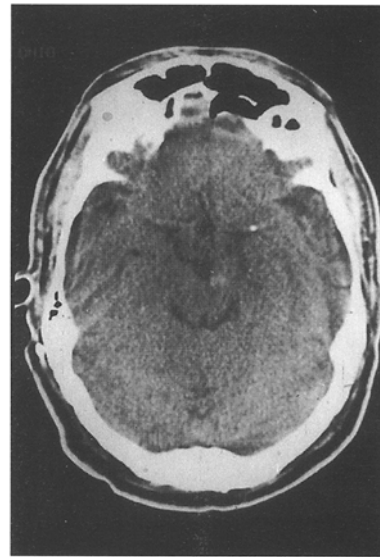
Postoperative brain CT showing a small haemorrhagic lesion in the ventromedial part of the left cerebral peduncle
